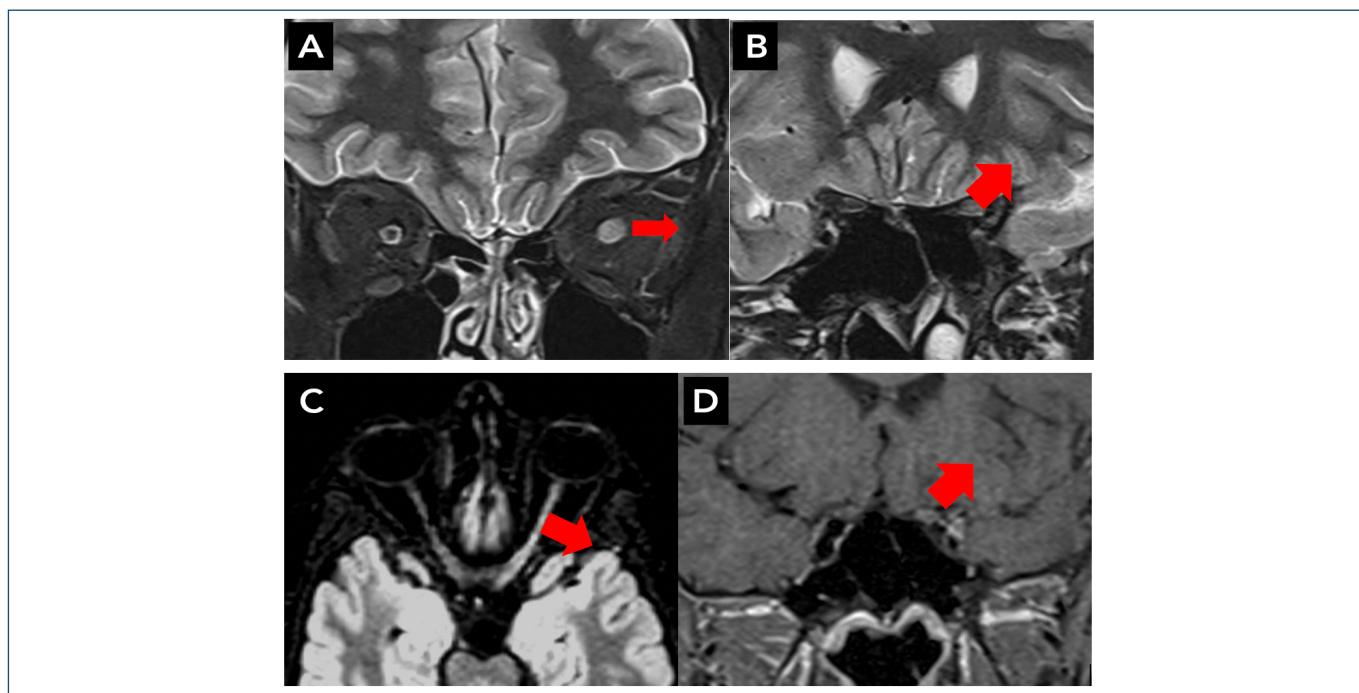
Magnetic resonance imaging of the orbits reveals increased signal intensity in left optic nerve on coronal T2-weighted images in intraorbital (A) and canicular (B) segments (arrows). The axial T2 FLAIR-weighted image shows full extension of the nerve involvement (C) (arrow). Coronal T1-weighted image depicts the perineural enhancement around the left optic nerve (arrow) (D).
